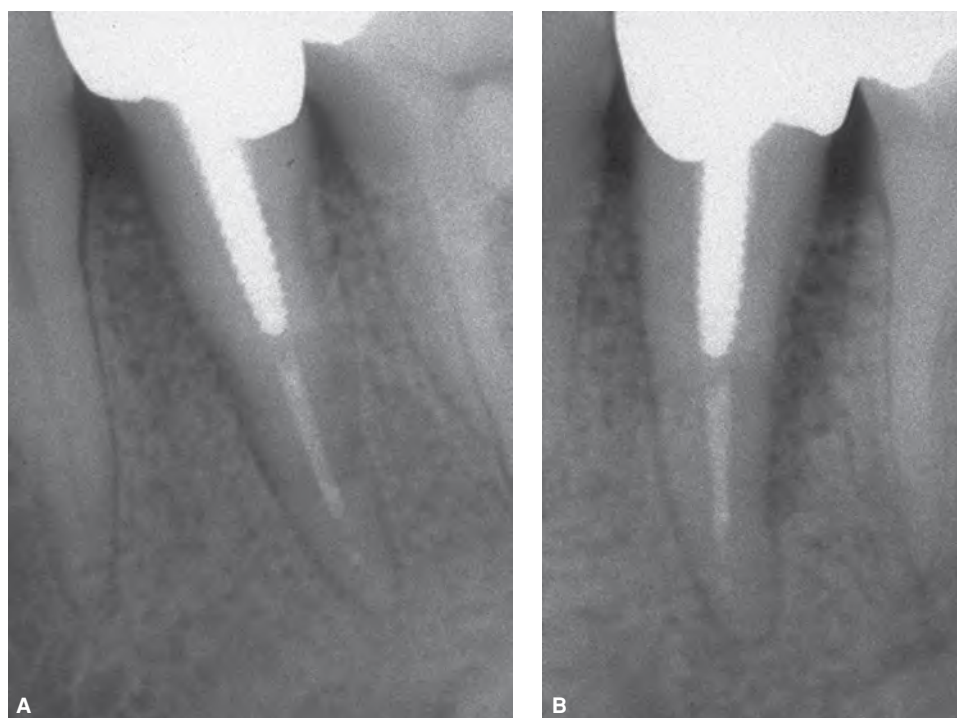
A. Periapical radiograph of a mandibular premolar reveals widening of the periodontal ligament space on the mesial tooth aspect. B. Change of horizontal angulation reveals radiolucency along most of the distal part of the root from the coronal aspect, not involving the periapical area (periodontal radiolucency).
